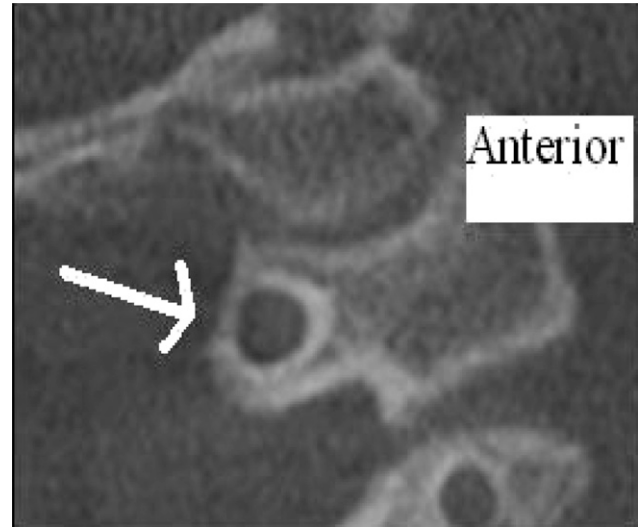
Cone beam CT sagittal section visualizes a complete Class 4 ponticulus posticus on the left side of the atlas of a 14-year-old black female (arrow).
